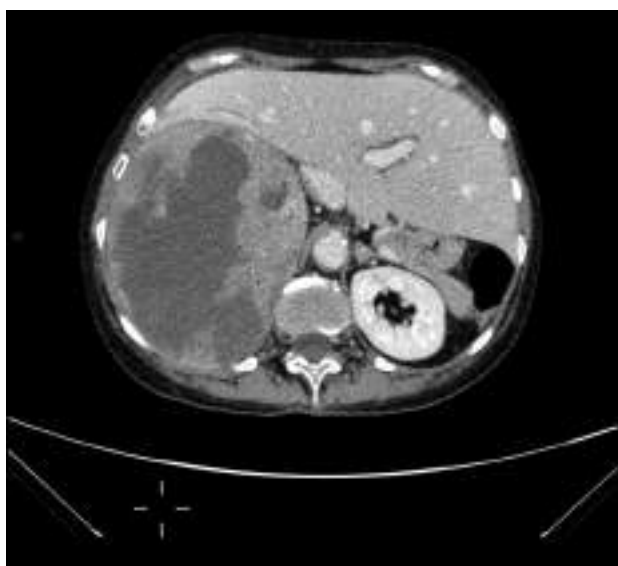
Axial CT scan of the abdomen – Renal cell carcinoma
